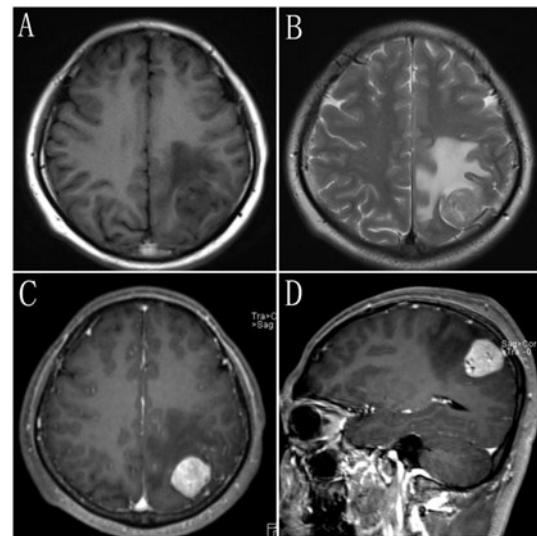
MRI plain scan and enhancement. A type of round mass was found in the left parietal lobe with clear boundary and size of 28×25×29mm. TIWI (A) shows uneven low signal and T2WI (B) shows uneven high signal. Contrast-enhanced scan (C, D) shows obvious enhancement of the lesion with spot-like areas without enhancement, compression of adjacent brain tissue, and large fluid signal shadows around the lesion.
